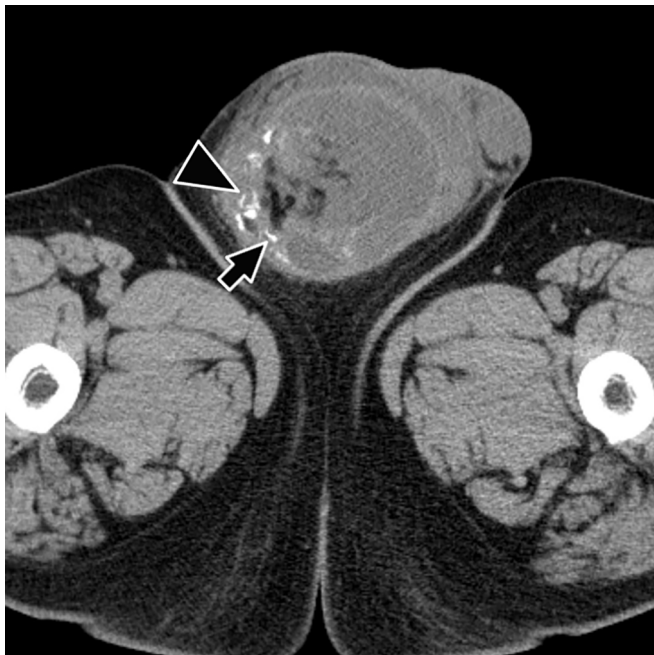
Computed tomography (CT) of the scrotum. CT revealed a right testicular mass, approximately, 10 cm, with calcification (arrowhead) and fat components (arrow).
